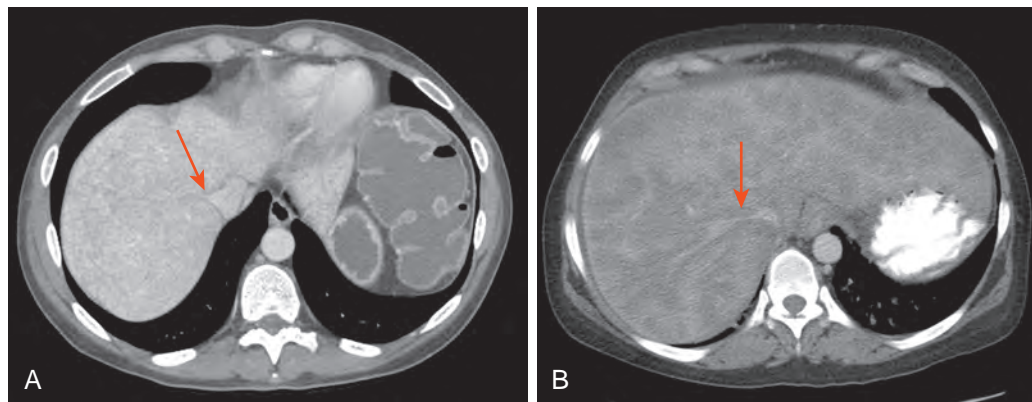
Sinusoidal obstruction syndrome: CT findings. Axial CT images in two different patients (A and B) show a mottled contrast enhancement pattern and narrowing of the right hepatic vein (arrows). This latter finding is suggestive of sinusoidal obstruction syndrome in the appropriate clinical setting.
